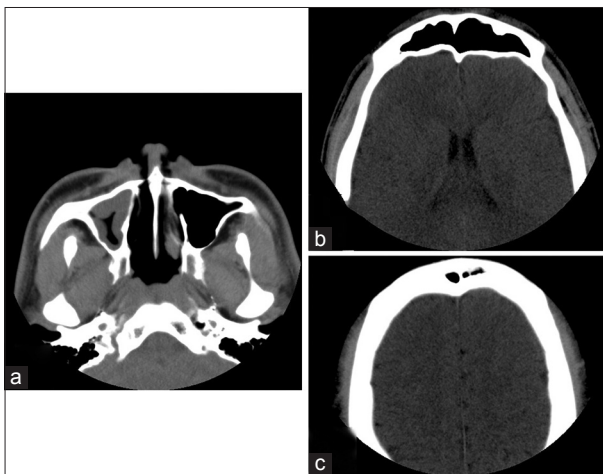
Computed tomography taken at the first consultation. (a) There was a fluid collection in the right maxillary paranasal sinus. (b and c) There were no abnormal findings in the cranium
